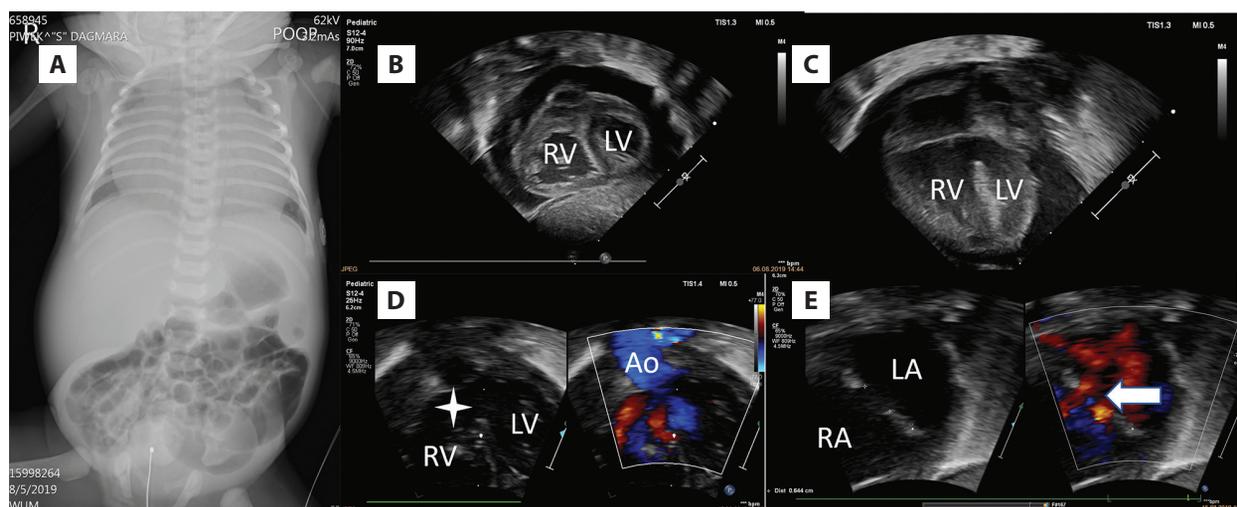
A. Chest and abdomen X-ray with an antero-posterior view showing extreme cardiomegaly, hepatomegaly, and distended intestines. B. TTE. A subcostal view showing cardiac tamponade. C. TTE. Four-chamber view showing cardiac tamponade with right atrial and ventricular enlargement and large ventricular septal defect. D. TTE. Five-chamber view showing large ventricular septal defect (the white star). E. TTE. Subcostal view showing atrial septal defect with two L-R shunts (the white arrow)
